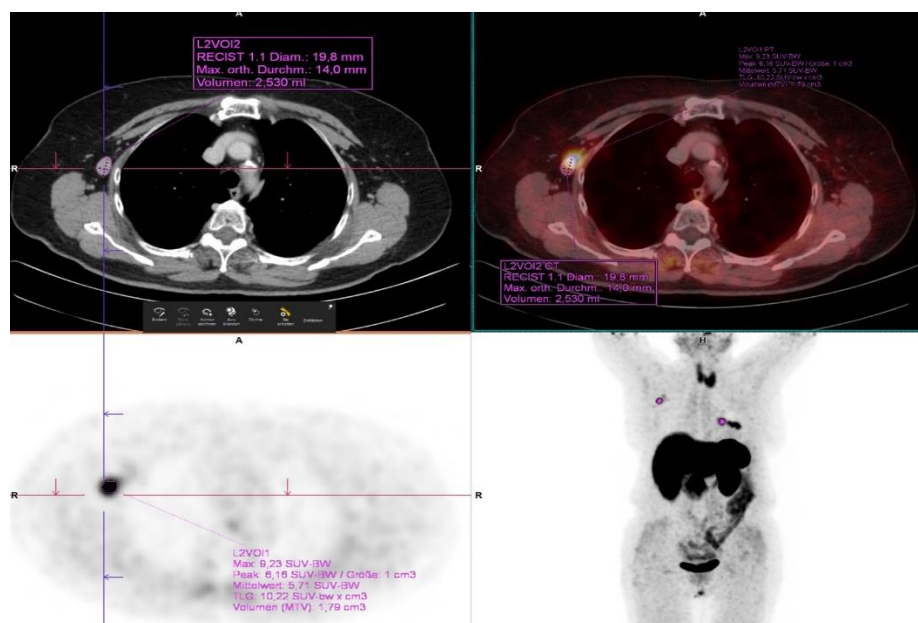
68Ga-Dotatoc-PET/CT of an 83 years old woman. Ga-Dotatoc avid somatostatin receptor-positive solid tumor in left upper lobe and left hilar lymph node metastasis. The CT, axial fused, PET and Maximum Intensity Projection (MIP) shows PET-positive right sided axillary lymphadenopathy.
